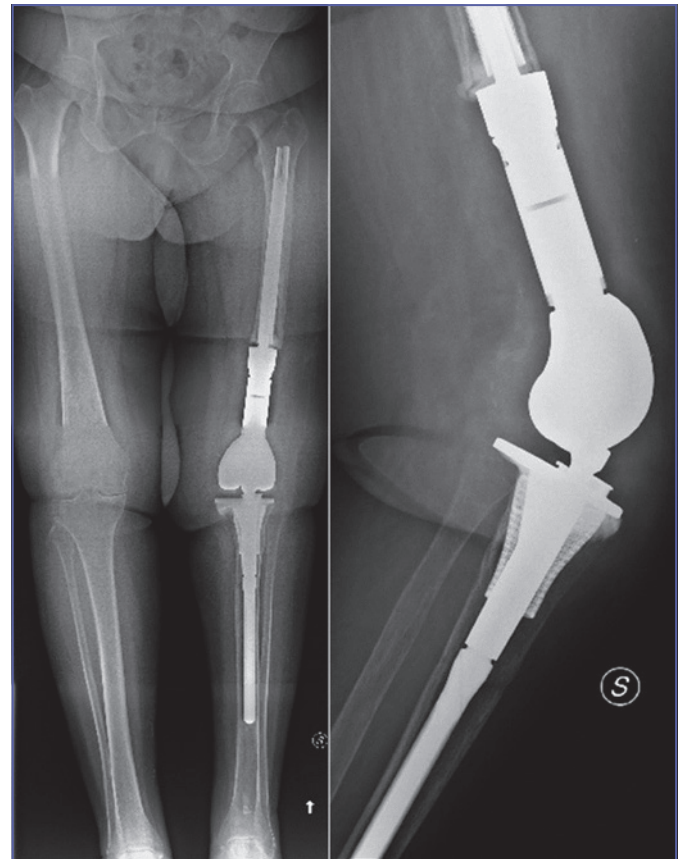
Postoperative x-rays at 1-year follow-up showing optimal alignment and no radiolucent lines, loosening or implant migration.
